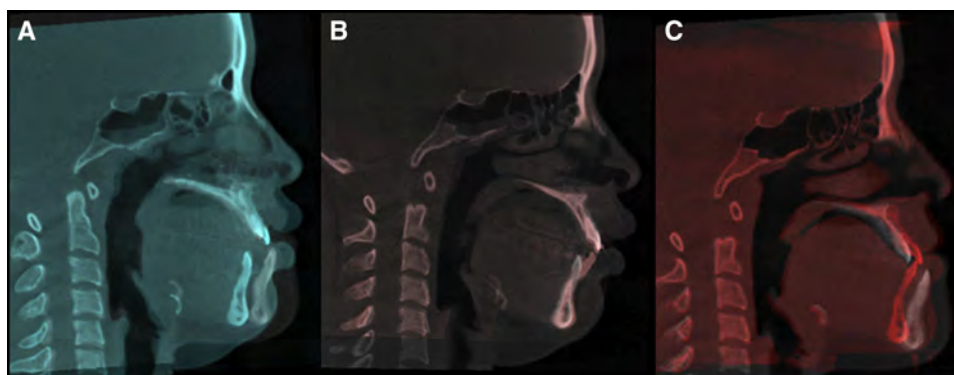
Superimpositions of pretreatment and posttreatment tracings based on cephalograms generated from CBCT volume images.
